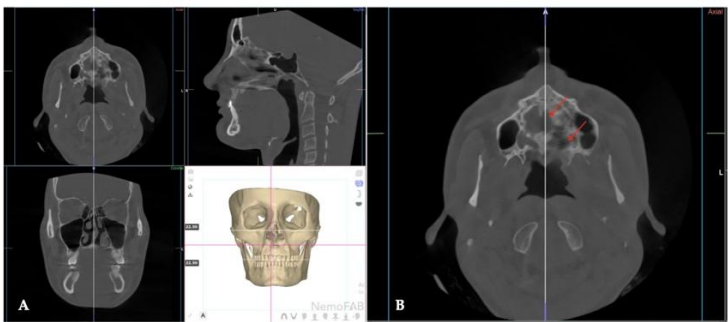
Sixteen (16) months since the beginning of treatment with 12 months since the expansion completion. A - skull orientation is consistent with two other CBCTs taken at 0, and 4 months of treatment, respectively. B - Close up axial view of the palate demonstrating near complete ossification of the palatal processes fusion at the midpalatal junction and residual remodeling in the middle third of the palate. The remodeling is also evident at the level of the fracture of the left palatine bone. (Arrows).
